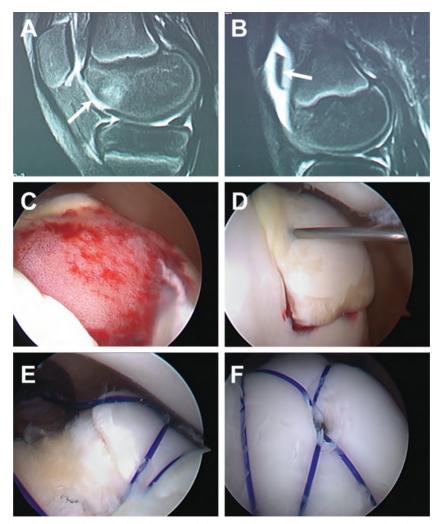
Case example of suture-bridge used to secure a large thinly delaminated osteochondral lesion. A 12-year-old male presented after minimal trauma to his left knee complaining of pain and mechanical symptoms. (A&B) Sagittal T2-weighted MRI imaging revealed a chondral delamination of the medial trochlea with an associated large loose body (arrows). (C&D) Intraarticular arthroscopic photos demonstrating the large lesion and provisional fixation of the large free fragment. (E&F) Arthroscopic photos at the anterosuperior edge and the center fixation points following secure fixation with 5 Pushlock anchors and 0 Maxon suture.
